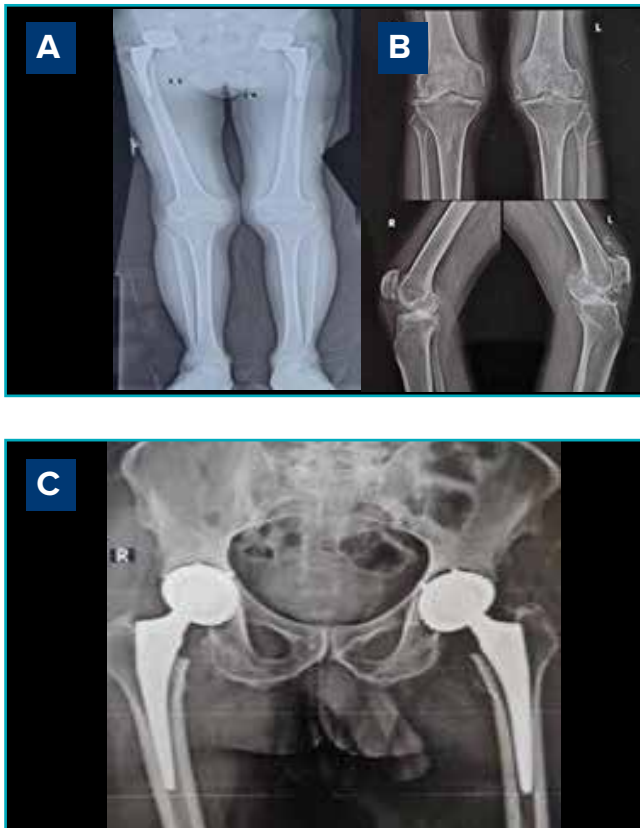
A. Scanogram of both lower limbs, B. Radiograph of the knee (anteroposterior standing and lateral view) showing a severe osteoarthritic knee, C. Six months follow-up of bilateral total hip replacement.
